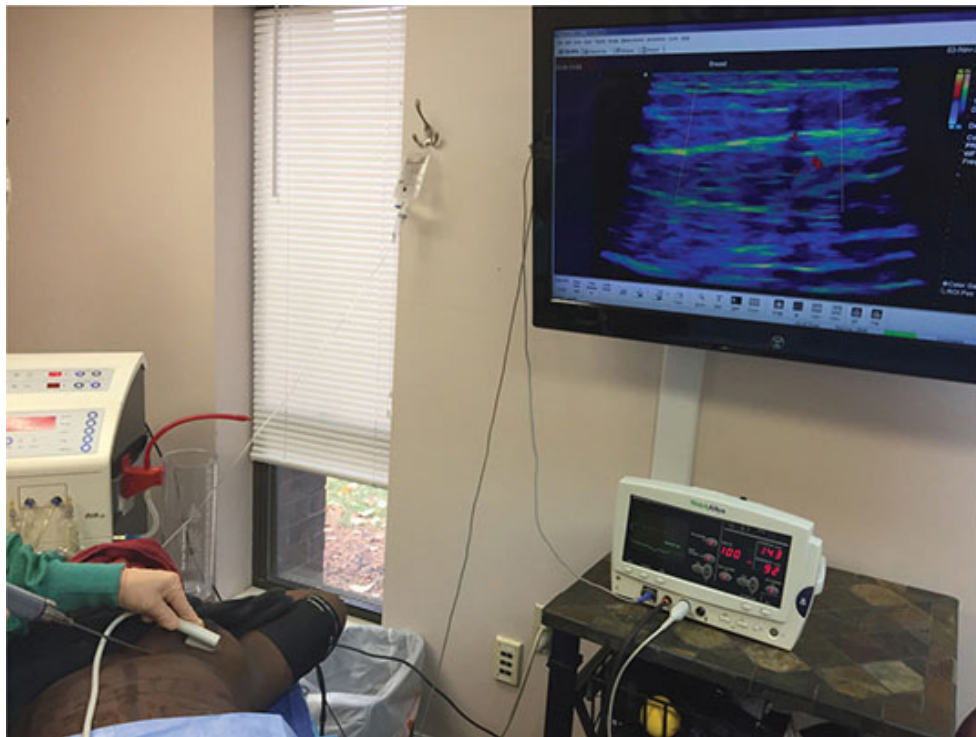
Fat grafting to large body areas—Fat transfer to large body areas is performed under continuous ultrasonic guidance in the operating room.
